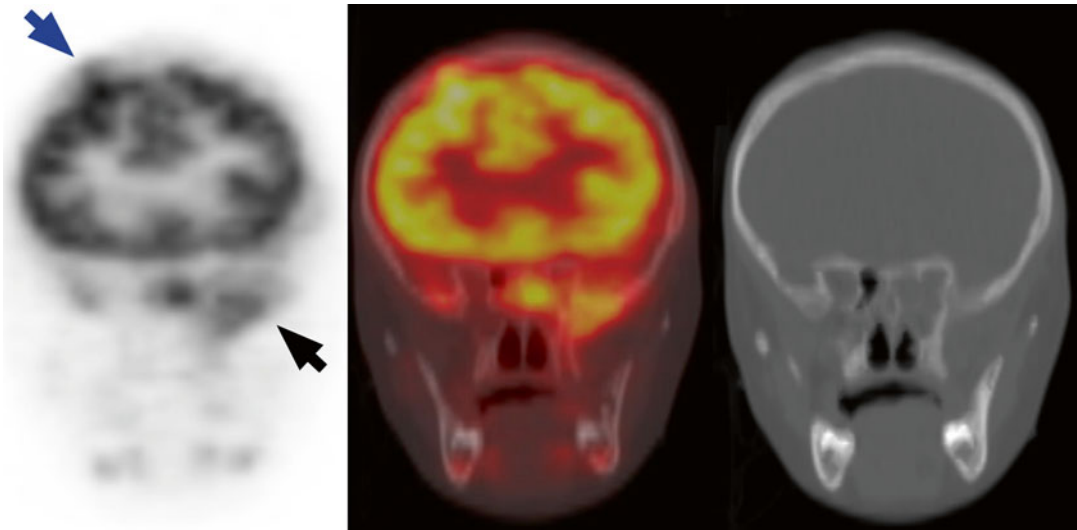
Patient with stage 4 neuroblastoma also shown in Fig. 19.7. Coronal ^{18}F -FDG PET/CT images show abnormal uptake within the large right frontal (blue
